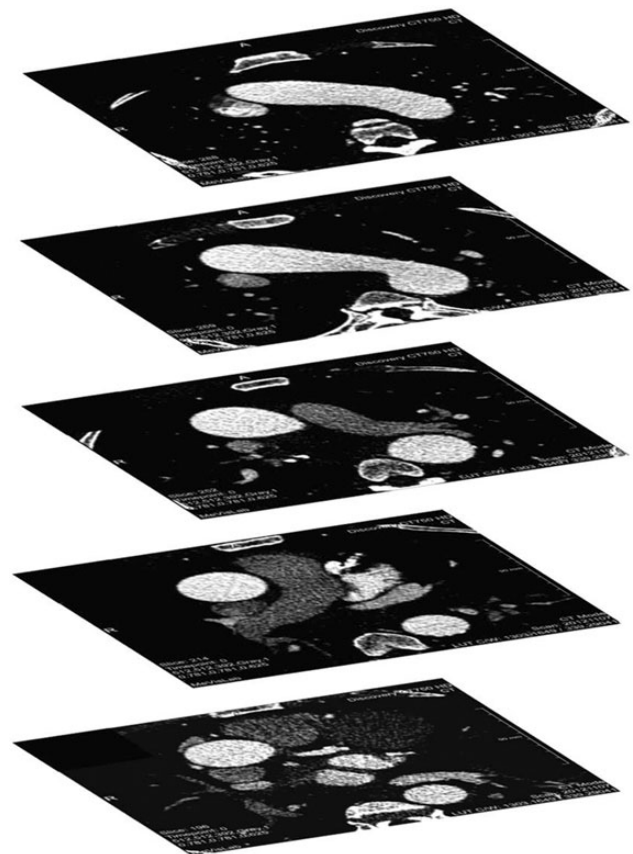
Computed tomography scan images used for surface reconstruction.
